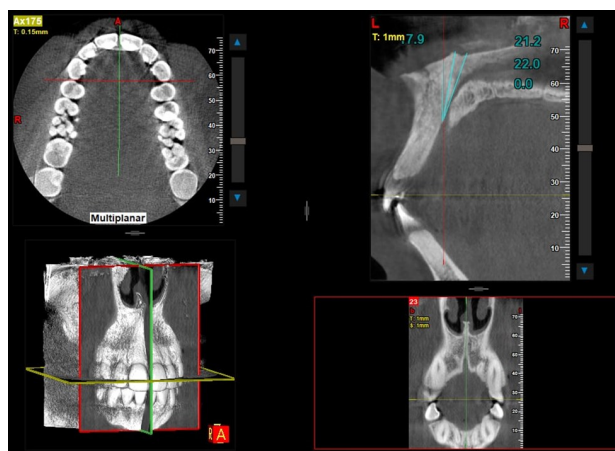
Palatal Thickness Measuring Using CBCT
